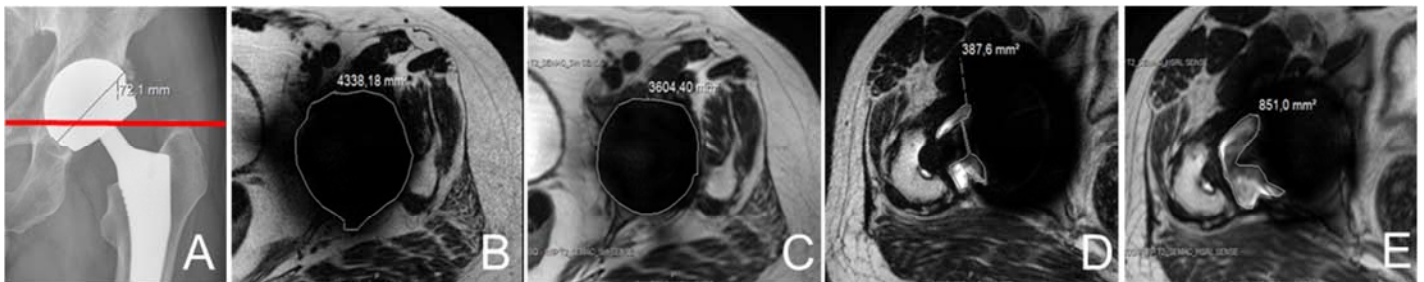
The diameter of the acetabular cup was measured using X-ray (A). Sample axial images and artifact contours positioned at the crossing of the acetabular head and the femoral part (red line) are shown for T2w in (B) and for T2w SEMAC (C). The effect of imaging closer to the implant is shown for the maximal extent of fluid and pseudotumor in conventional T2w (D) and T2w SEMAC (E).
